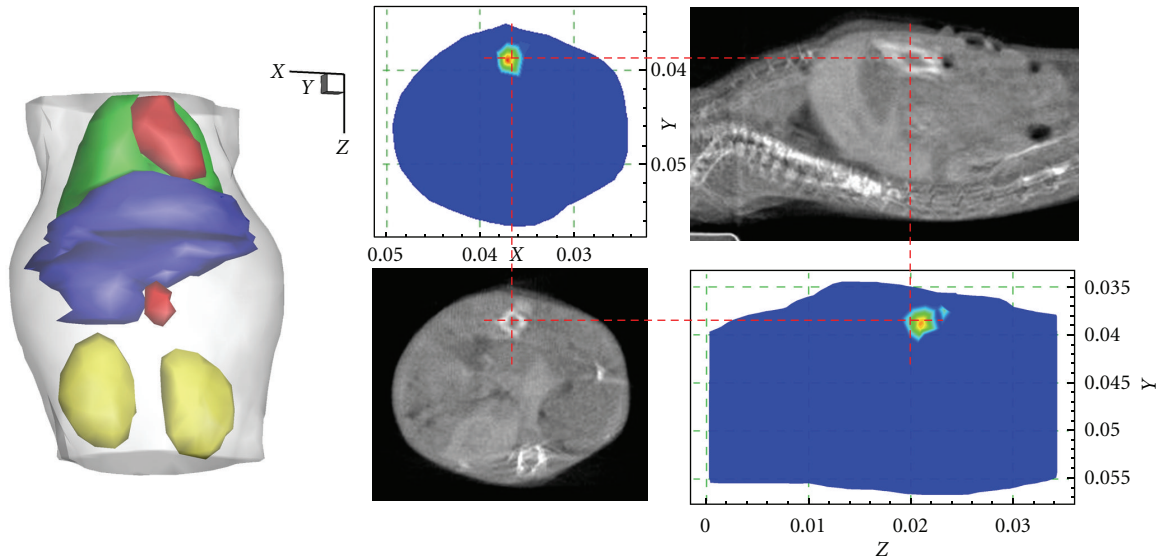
The reconstruction results. The results are shown in the form of isosurface for 40% of maximum value (left column) and slice images (right column). The transverse view of the results and the comparisons with the corresponding CT slices. The cross of the red lines denotes the actual source center.
